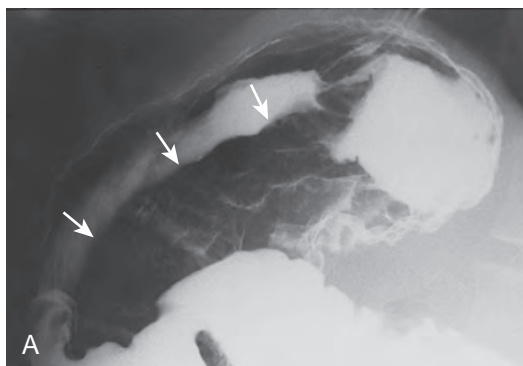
Gastric involvement by a pancreatic pseudocyst. A. Barium study shows smooth extrinsic compression (arrows) of the posterior wall of the gastric fundus. B. CT scan reveals a large pancreatic pseudocyst (arrow) as the cause of this finding.
